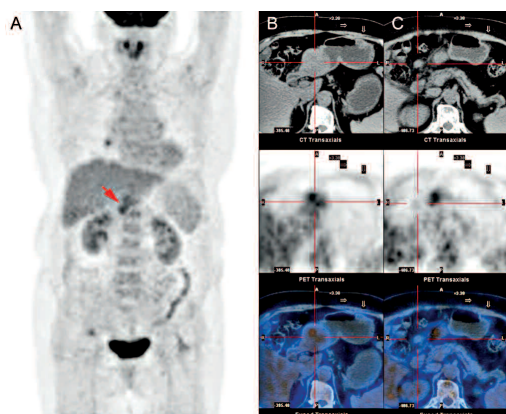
Maximum intensity projection images showed an intense hypermetabolic focus in the stomach (A, arrow). Transaxial views of the antral mass were observed with an overlay of CT, PET, and PET/CT images with a SUVmax of 4.5 (B). An ^{18}F -FDG PET/CT scan also showed ^{18}F -FDG accumulation in the lymphadenopathy with a SUVmax of 1.3 (C).
